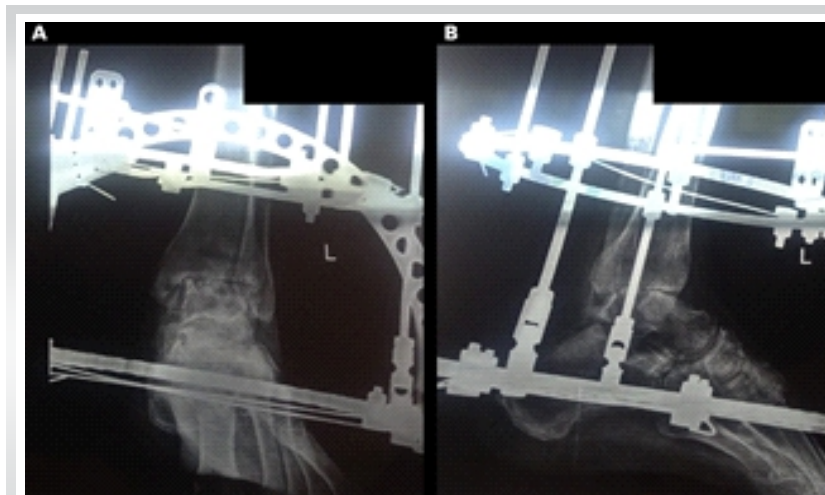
AP (a) and lateral (b) radiographs of the left ankle at 9-month follow-up, following ring fixator-assisted arthrodesis. The images demonstrate progressive trabecular bridging across the tibiotalar arthrodesis site with the Ilizarov frame in situ, consistent with ongoing bony consolidation. AP: Anteroposterior.
